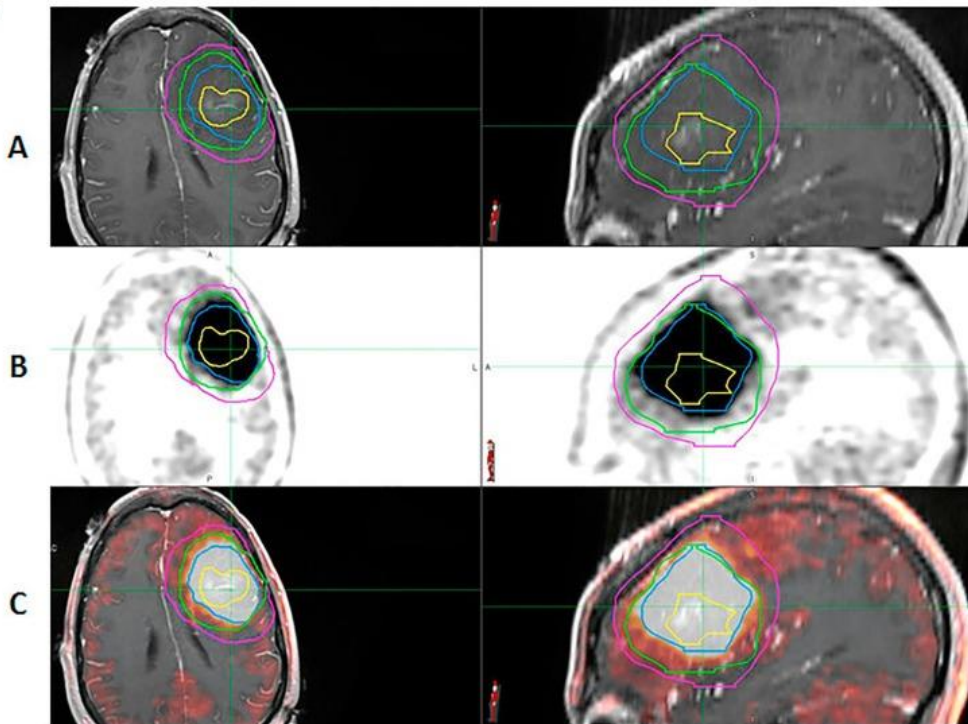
Example of difference in 60 Gy target volume between MRI and MRI + PET in T1-CE patients. The upper row is the T1-CE MRI (A), the middle row is the T1-CE 2016 WHO grade IV tumor (glioblastoma), and the corresponding ^{18}F FDOPA PET (B) image of patient FDOPA 03, in lower row with MRI + PET fusion(C). A row showing an increase in 60 Gy target area coverage with PET scans above MRI T1-CE. Legend: Blue = $\text{BTV}_{60\text{Gy_PET}}$; Yellow = $\text{GTV}_{60\text{Gy_MRI}}$; Magenta = $\text{PTV}_{60\text{Gy}}$ (MRI + $\text{BTV}_{60\text{Gy_PET}}$ + $\text{GTV}_{60\text{Gy_MRI}}$ extension for PET planning); Green = $\text{PTV}_{60\text{Gy}}$ MRI ($\text{GTV}_{60\text{Gy_MRI}}$ extension for pure MRI planning).
